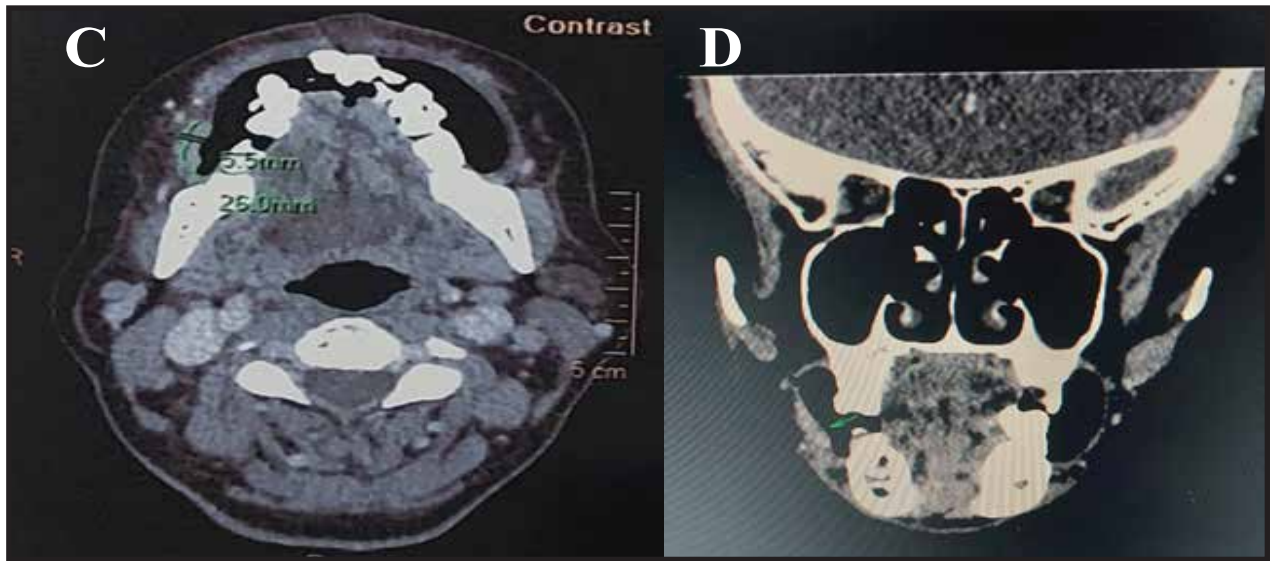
55-year-old woman with invasive squamous cell carcinoma of the right buccal mucosa. (a, b) Conventional axial, coronal CT scan through the occlusal plane is normal. (c, d) Puffed-cheek axial, coronal CT scan shows an enhancing nodule on the right buccal mucosa. The buccal mucosa and buccinator muscle together form an irregular soft tissue band.
